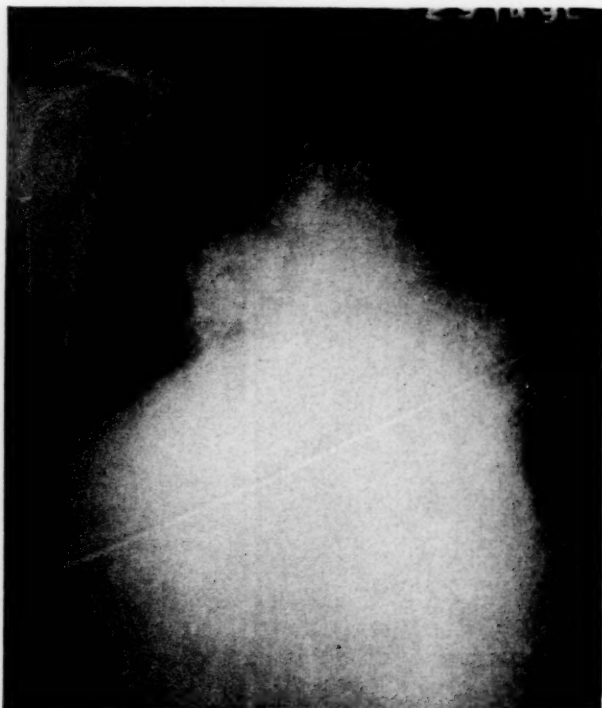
X-ray taken six weeks after completion of radiation therapy, Case v.
